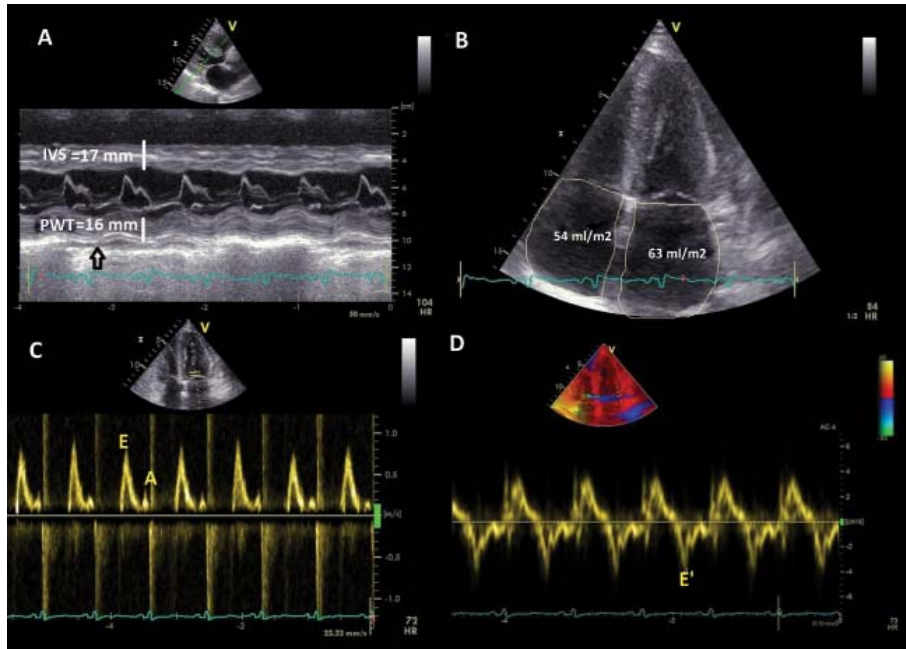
Transthoracic echocardiographic images for left ventricle showing A: severe concentric left ventricular hypertrophy (IVS=17 mm, PWT =16 mm, RWT =0.8, LV mass = 157 g/m²) B: biatrial dilatation (LA volume = 63 ml/m²; RA volume = 54 ml/m²) C and D: restrictive filling pattern (E/A=3, E=97 cm/sec, E' lateral = 4 cm/sec E'/E=25). IVS: interventricular septum; PWT: posterior wall thickness; RWT: relative wall thickness; LV: left ventricle; LA: left atrium; RA: right atrium. E=peak of early filling velocity; A=peak of late atrial filling velocity; E'lateral = lateral mitral annular peak early diastolic velocity.
